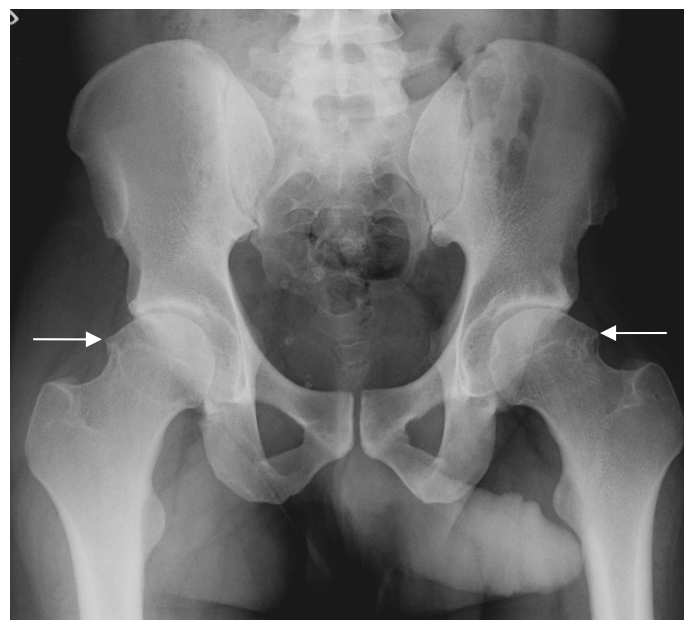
(A). AP Pelvis radiograph demonstrates an abnormal focal protuberance at the level of the femoral head-neck junction bilaterally (white arrows) sometimes referred to as a femoral neck "bump." There are osteoarthritic changes of both hips, worse on the left than right.
